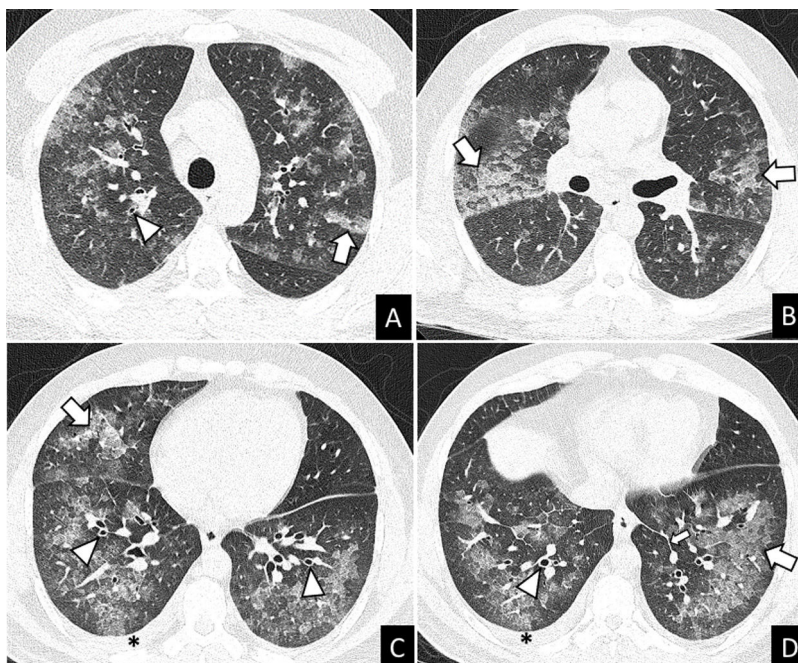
Unenhanced chest-CT. (A–D) Axial views. The CT scan showed bilateral ground glass opacities (GGO) and consolidation with smooth interlobular septal thickening (arrows), peribronchovascular thickening (arrowheads), and mild bilateral pleural effusion (asterisks).
